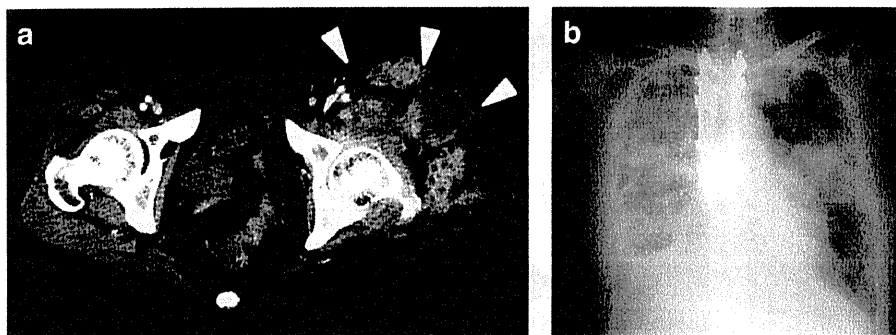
(a) An enhanced computed tomography image of the pelvis 5 weeks after the initial curettage. (b) A plain chest X-ray taken 11 weeks after the initial curettage showing multiple metastatic tumors and pleural effusion in the lung.
